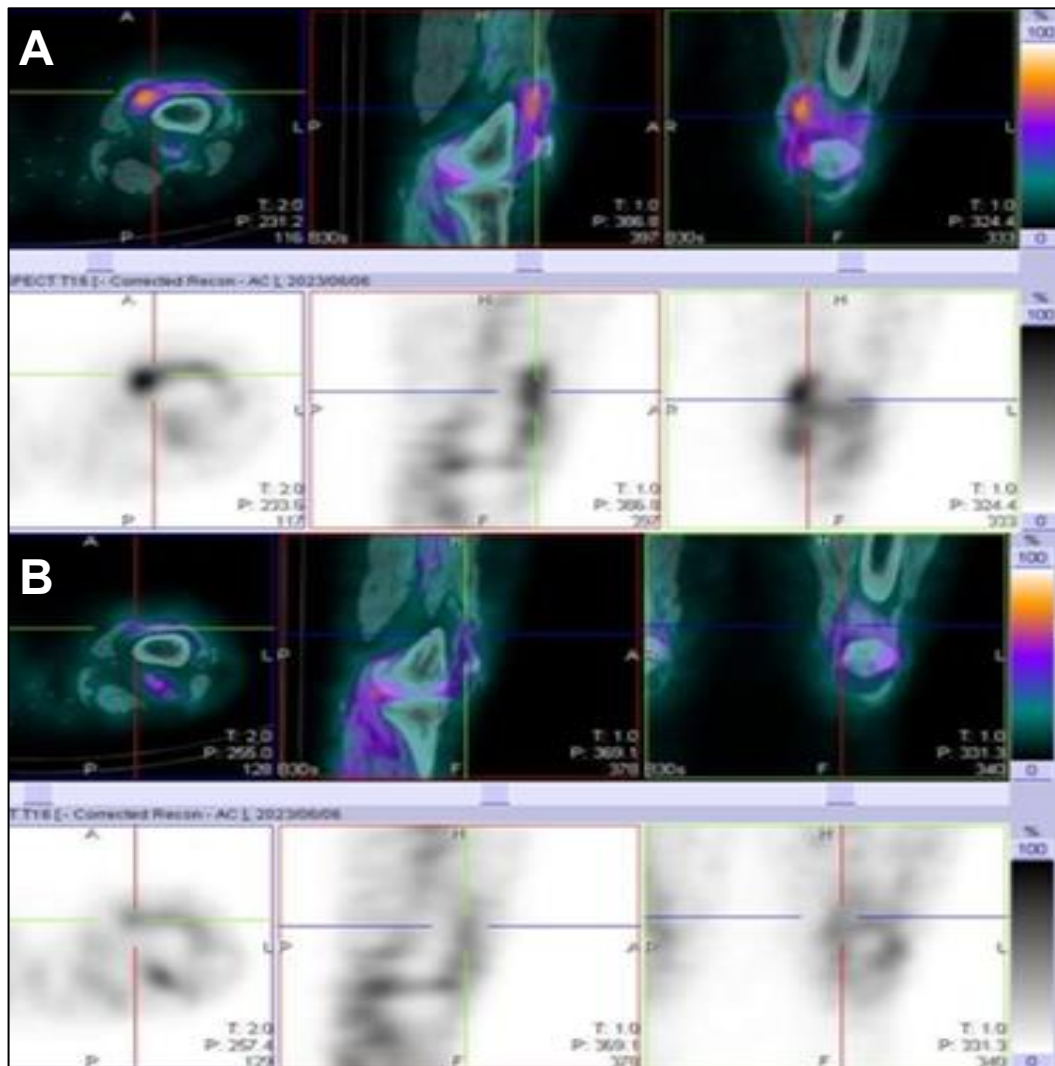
61-year-old female with fully resolved disease. SPECT/CT and SPECT images in the top row (A) show increased grade 3 uptake in the medial compartment of the left knee joint, in keeping with medial synovitis. SPECT/CT and SPECT images performed after 6 months (B) show fully resolved disease
